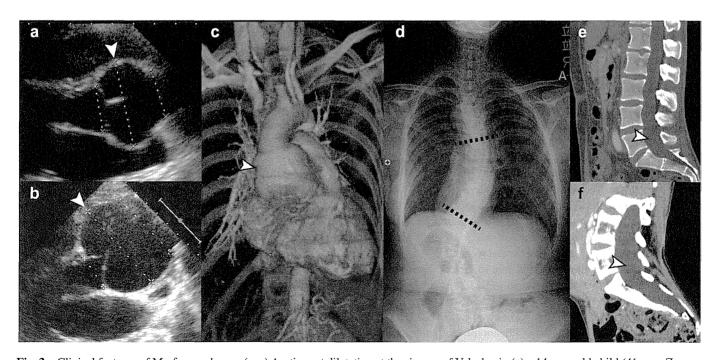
Clinical features of Marfan syndrome. (a–c) Aortic root dilatation at the sinuses of Valsalva in (a) a 14-year-old child (41 mm, Z score = 5.9; echocardiography), and (b,c) a 30-year-old woman (68 mm, Z score = 15.0; b, echocardiography; c, computed tomography [CT] angiography). Arrowhead, dilated aortic root. (d) Scoliosis with a Cobb's angle >20° (two dotted lines), in a 36-year-old woman with lumbago. (e,f) Dural ectasia with an elevated dural sac ratio (dural sac diameter/vertebral body diameter)¹⁸ in the lumbosacral spine (L1–S1) in (e) a 32-year-old man (CT) and (f) a 13-year-old child (CT). Arrowhead, dilated dural sac.
